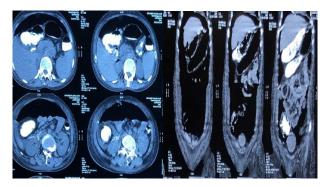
CT Abdomen showing moderate pneumoperitoneum.
